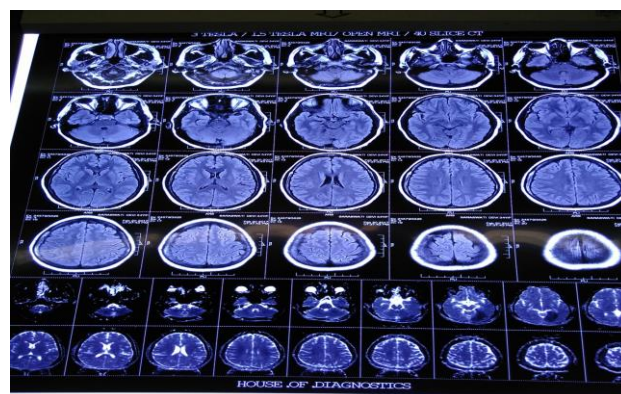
MRI brain showing area of restricted diffusion in medial- parasagittal aspect of left occipital lobe, representing acute infarct.
